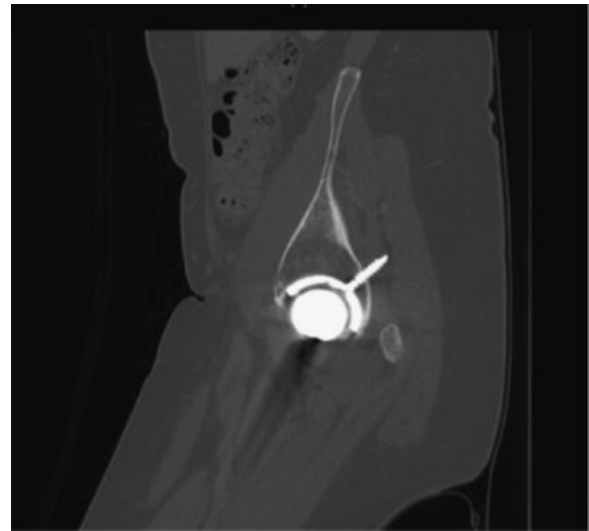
CT scan of hip showing malpositioned and long acetabular cup screw.
